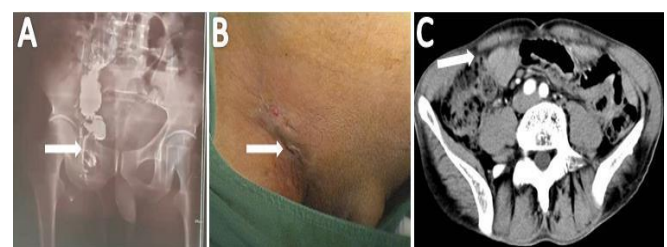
Preoperative examination data of the patients. (A) Radiography of the right inguinal fistula showed a sinus tract in the right inguinal area, which communicated with the small intestinal cavity. (B) Physical examination showed that his abdomen was flat and soft, and a 0.5×0.5 cm external fistula was seen in the right groin area. (C) Abdominal computed tomography (CT) showed a sinus tract in the right groin area, with an unclear boundary between the inner opening and the small intestine.
